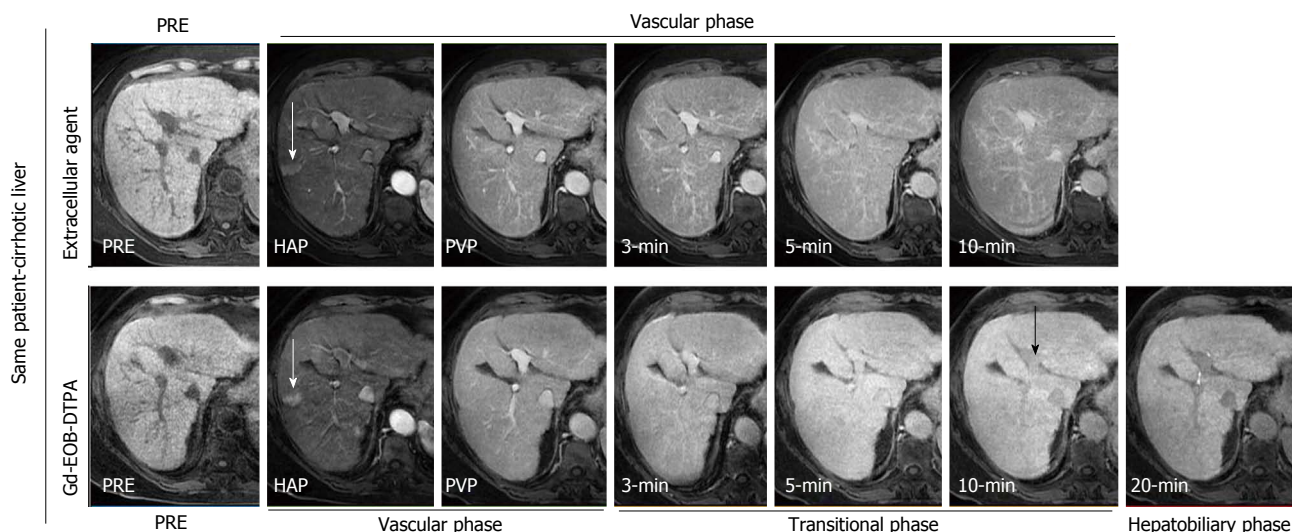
Intraindividual differences in hepatic enhancement in cirrhotic liver between extra-cellular contrast agent (top row) and gadoxetic acid (bottom row) in a 69-year-old woman with hepatitis C virus-related cirrhosis. On contrast-enhanced magnetic resonance (MR) images obtained with an extra-cellular agent liver enhancement peaks on portal venous phase and then slightly decreases. On contrast-enhanced MR images obtained with gadoxetic acid, liver enhancement shows a stepwise increase from the hepatic arterial phase to the 20 min phase. Vascular enhancement is more prolonged with extra-cellular agent than with gadoxetic acid, indicating a slower vascular elimination. On 10 min, the intrahepatic vessels (black arrow) show slight hypointensity to the liver, and the bile ducts are not opacified. These findings indicate hepatic dysfunction and a prolonged transitional phase. Also, note a wedge shaped enhancing area in the hepatic arterial phase (white arrow), with lack of washout on portal venous phase and isointensity on hepatobiliary phase, due to arteriportal shunt. PRE: Precontrast; HAP: Late hepatic arterial phase; PVP: Portal venous phase.
